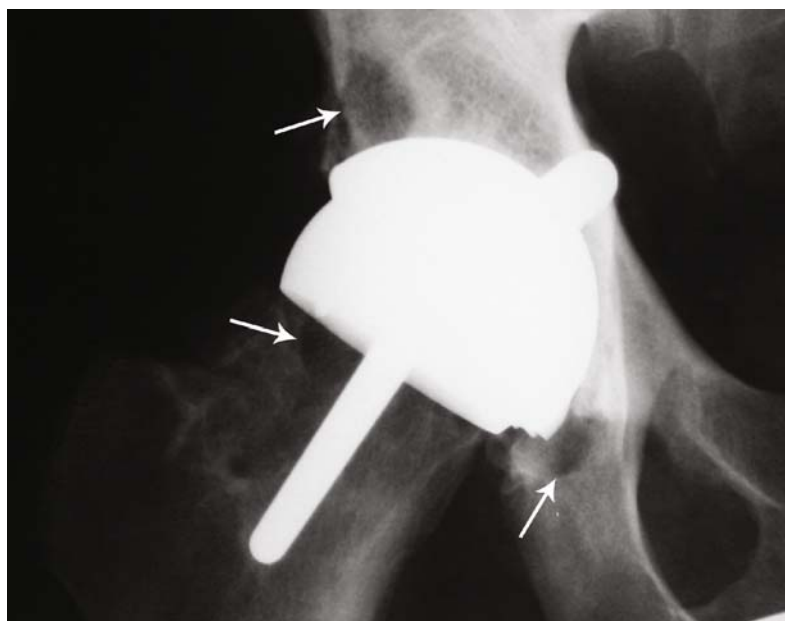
A 35-year-old man with McMinn Hybrid Resurfacing performed in 1996. Very minor symptoms at 10-year follow-up, but radiographic osteolysis (arrows) present in pelvis and femoral neck.
